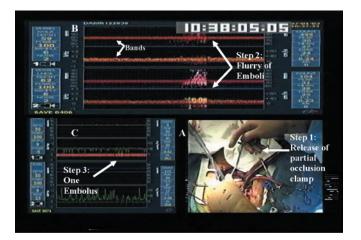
Surgical event/technique: release of partial occlusion clamp. A, Release of the partial occlusion clamp after the completion of the proximal anastomoses (step 1). B, Emboli and blood flow velocity in the right (top 2 bands) and left (bottom 2 bands) middle cerebral arteries. An embolus shows up in both bands because the embolus reflects ultrasound more strongly than the surrounding blood (step 2). C, Emboli and blood flow velocity through the cardiopulmonary bypass circuit (step 3). One embolus is noted.
